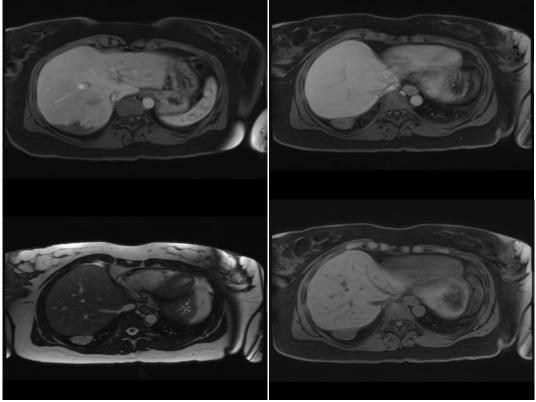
MRI liver and inferior thorax (axial sequences).
